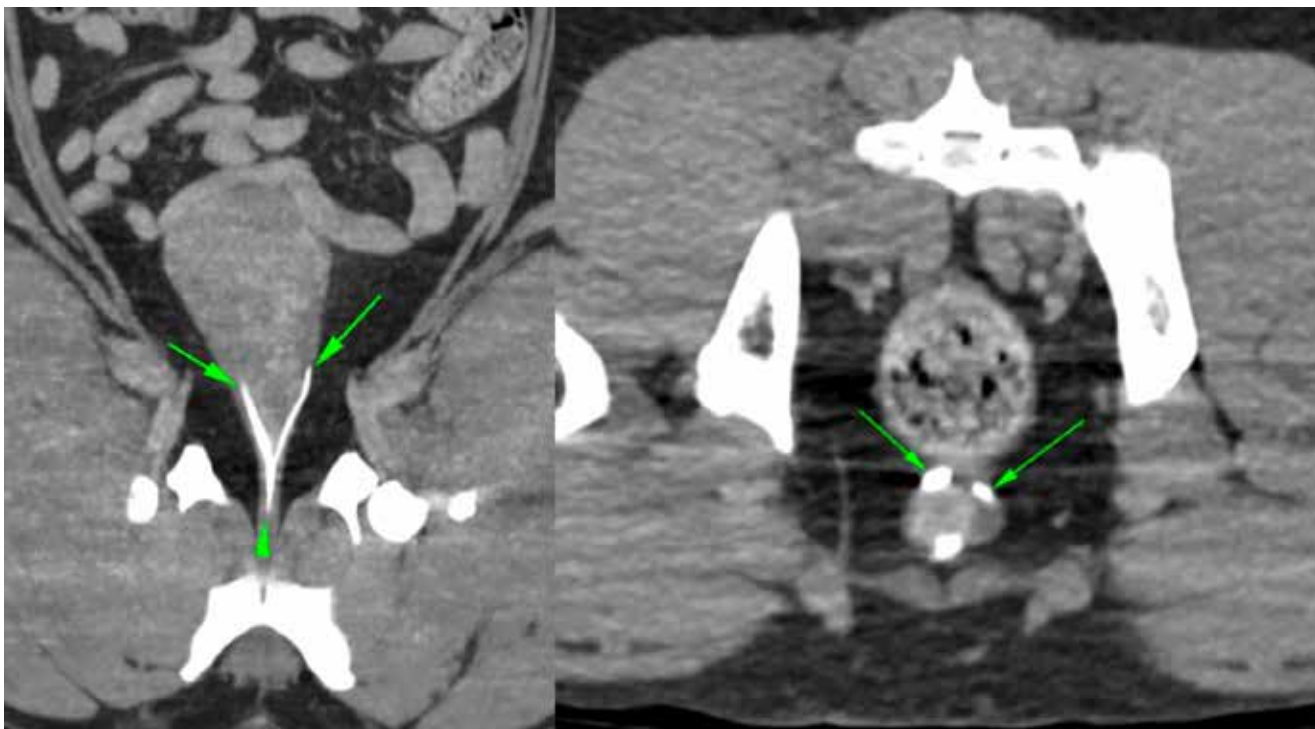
Bilateral intramural ectopic ureters noted on CT.
